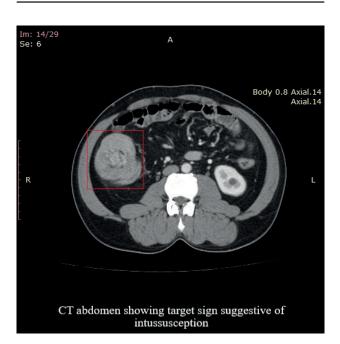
CT scan with ileocaecal intussusception.
